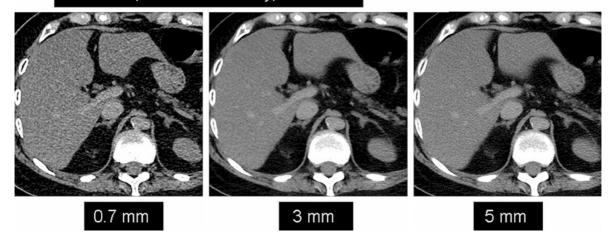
Transverse abdominal CT images reconstructed with at various section thicknesses (0.75, 3 and 5 mm). As slice thickness decreases, there is increase in image noise, so for primarily interpretation of routine studies, thicker sections must be used
